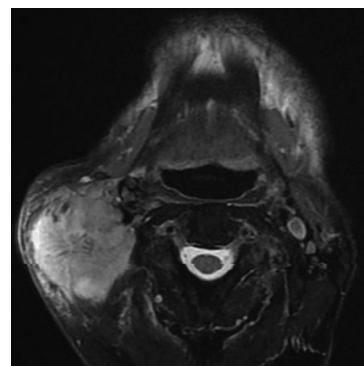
A magnetic resonance image with contrast enhancement representing a solid mass in the right parotid gland.
